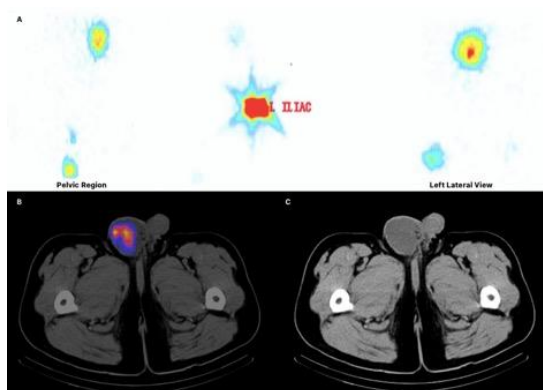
Epididymal cyst on the upper portion of the right testis. (A) planar scintigraphy. (B) SPECT/CT. (C) CT. Images depict increased radio-iodine uptake in the cervical region, left kidney and the right hemi-scrotum.
